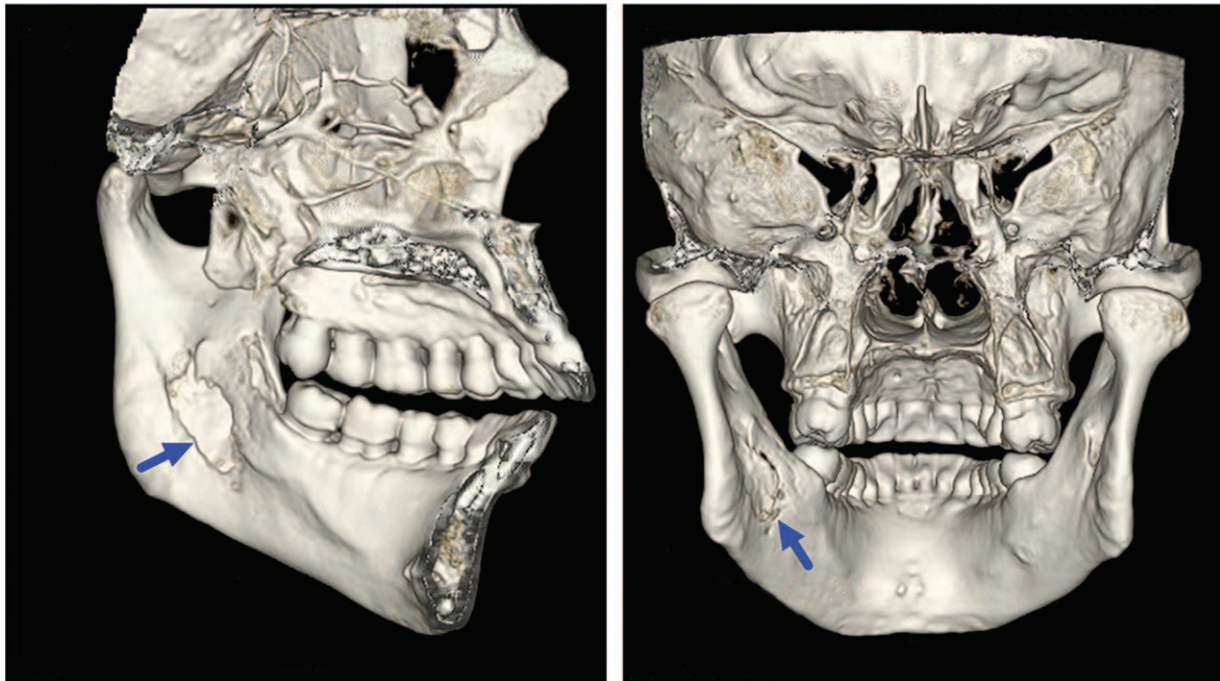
Radiography indicated a poorly defined, multilocular radiolucency located in the area of the left mandibular angle and ramus (arrow).
